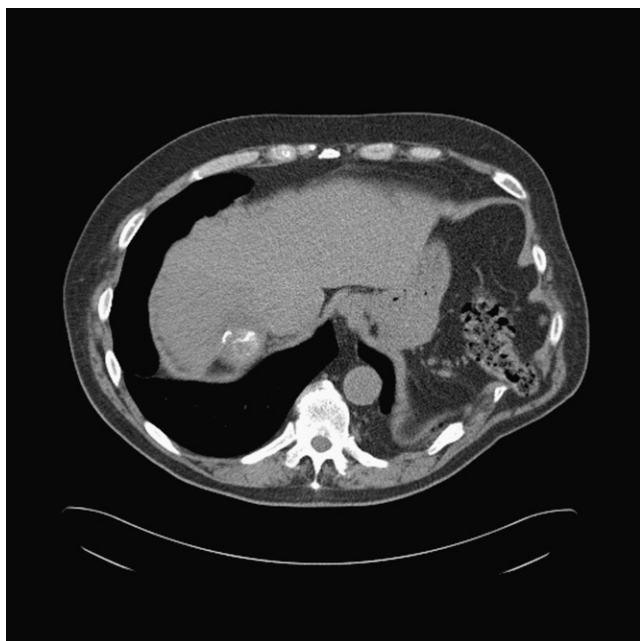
Axial view computed tomography scan of the chest displaying colon and diaphragm herniation.
